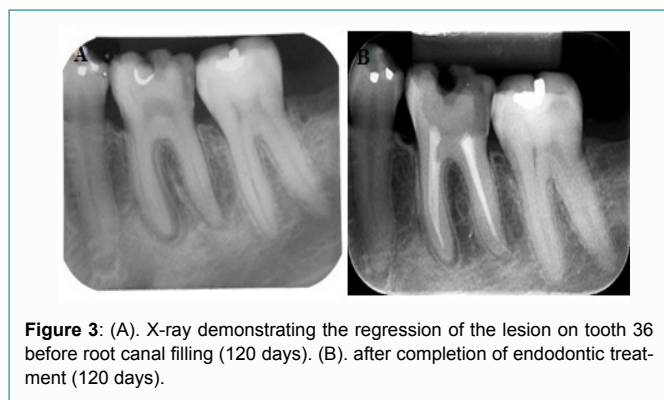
(A). X-ray demonstrating the regression of the lesion on tooth 36 before root canal filling (120 days). (B). after completion of endodontic treatment (120 days).
